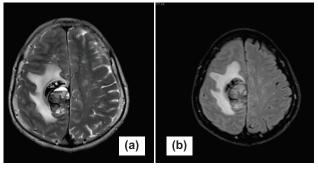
A) T2WI MRI showing heterogenous lesion with central area having fluid levels B) FLAIR image
